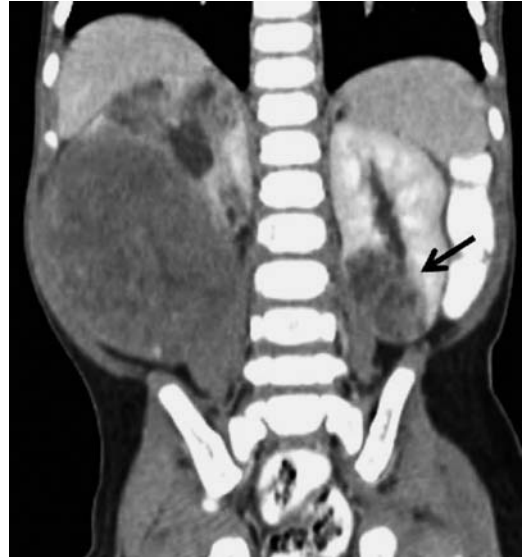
presents Wilms tumor with CT.
